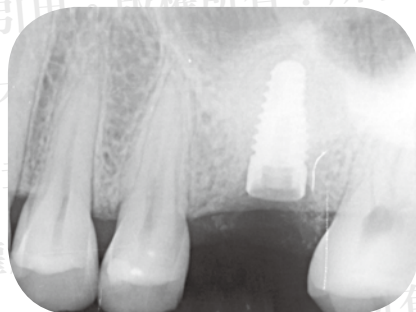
After retrieval of the fractured abutment screw, a radiograph was taken to confirm its complete removal.
